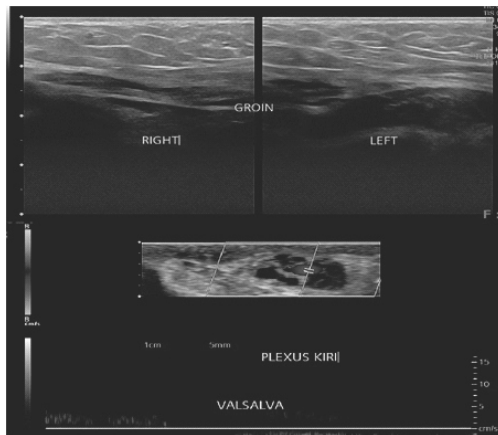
Colour doppler ultrasound showing dilated plexus pampiniform while valsava maneuver
